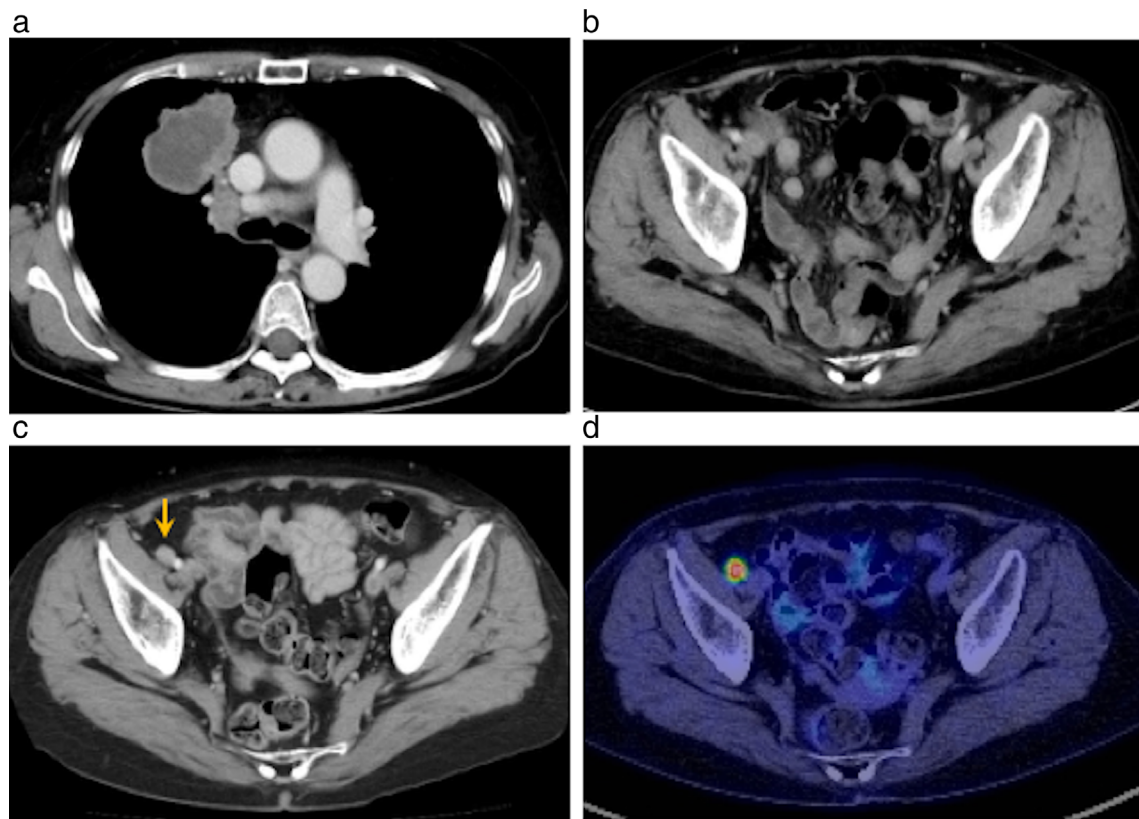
(a) Chest computed tomography (CT) revealed a mass in the right upper lobe of the lungs. (b) Baseline abdominal CT showed no lymph node swelling. (c) Abdominal CT and (d) positron emission tomography (PET) images revealed worsening of the right external iliac lymph node swelling (yellow arrow) with the accumulation of ^{18}F fluorodeoxyglucose activity
